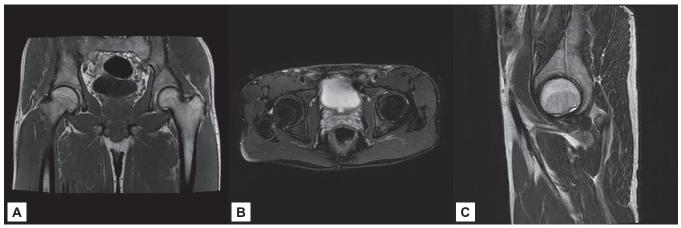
MRI views (A) Coronal view, (B) Axial view (C) Sagittal view.
